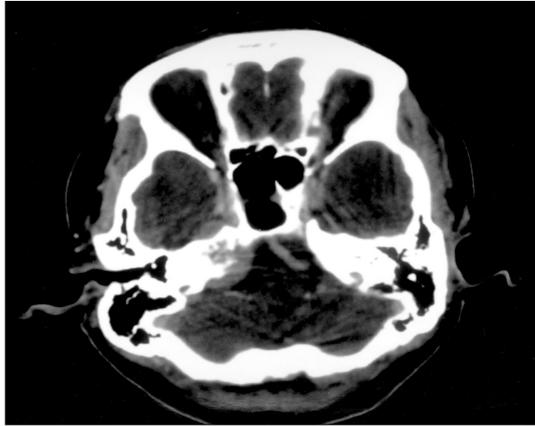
Axial view of posterior fossa CT scan shows enhancing soft tissue mass destroying right petrous bone and involving ipsilateral IAC.
